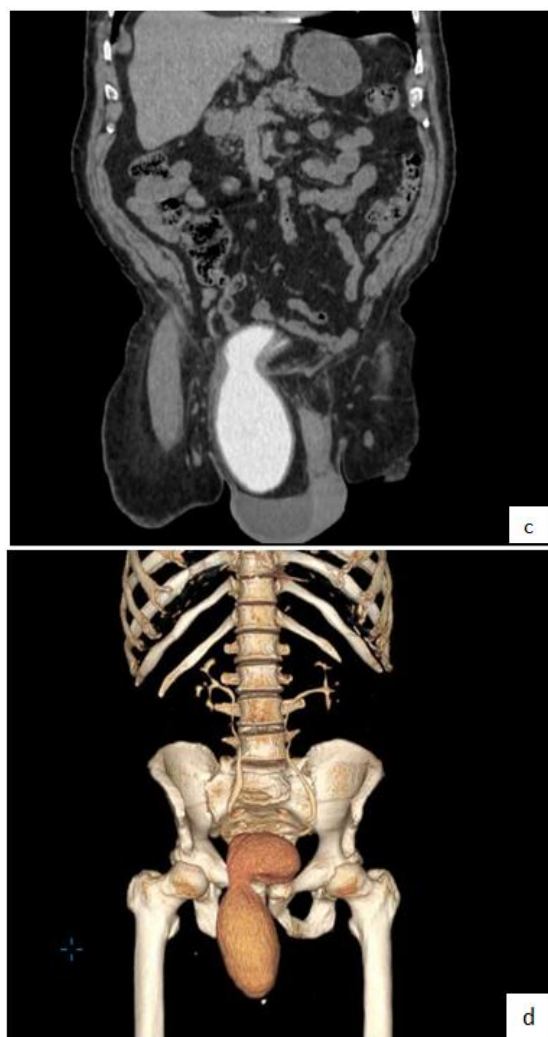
Uro-CT: Axial (a), sagittal (b), coronal (c) and 3D (d) sections at the delayed phase, showing a hernia of the left bladder horn at the inguinal level
